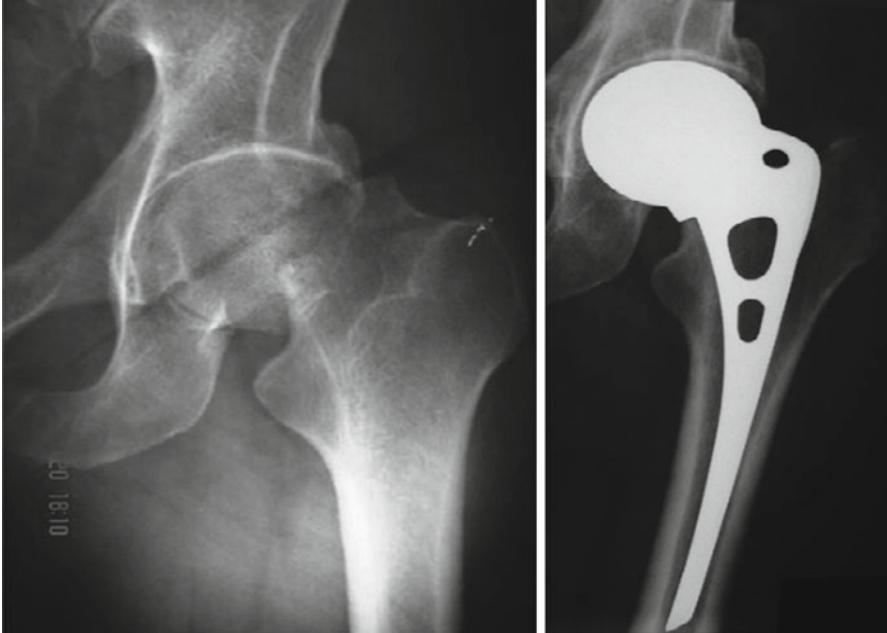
Radiographs showing a displaced intracapsular fracture (transcervical) of the left hip which has been treated by an Austin Moore prosthesis (Courtesy of Dilip Malhotra, Bahrain. Reproduced with kind permission of Springer Verlag)
